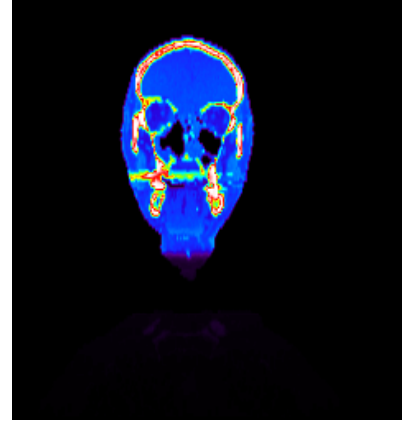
Central slices for Pat. B for a cone beam CT acquisition (360° tube rotation). The slice positions are marked in the CT-slices shown in (n) - (p).
